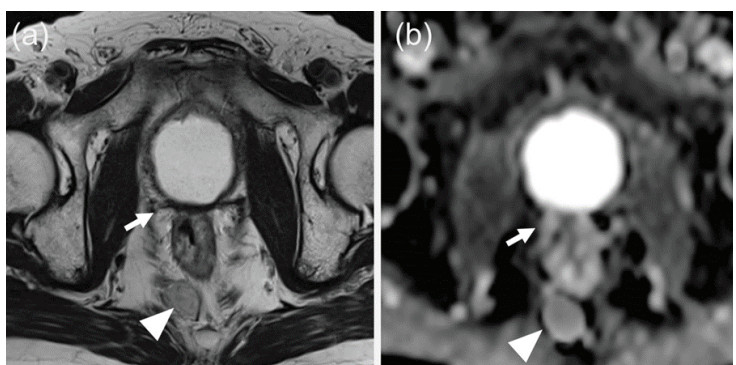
Magnetic resonance imaging five years after treatment. (a) Axial T2-weighted turbo spin-echo image showing no change in the size of the presacral nodule (arrowhead). There was no evidence of local recurrence of prostate cancer (arrow); (b) Apparent diffusion coefficient map showing no change in signal intensity of the presacral nodule (arrowhead). There was no evidence of local recurrence of prostate cancer (arrow).
